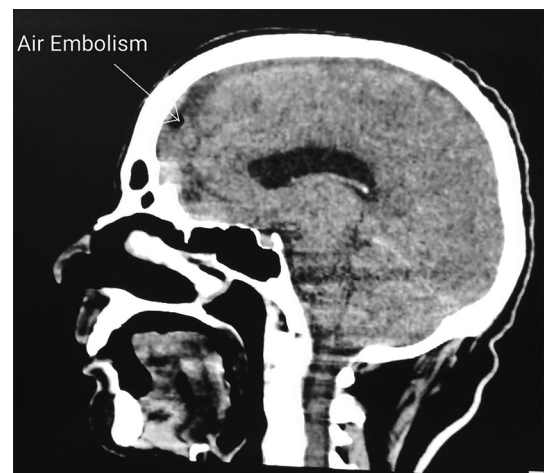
Sagittal image of computed tomography Brain showing air in the superior sagittal sinus
